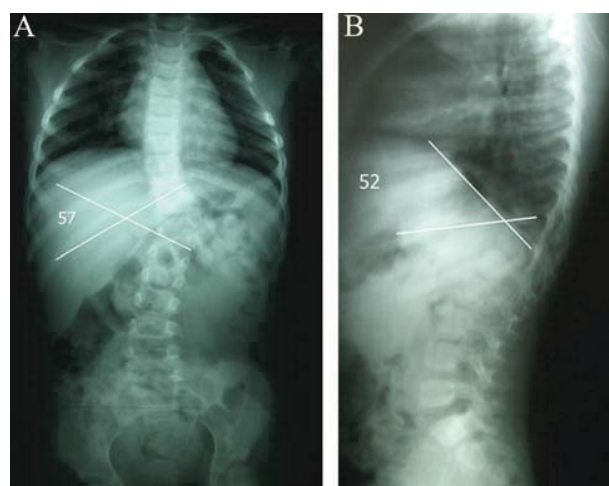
A, B, Preoperative anteroposterior and lateral radiographs showing a scoliotic curve measuring 56° and a kyphosis angle measuring 52°.
